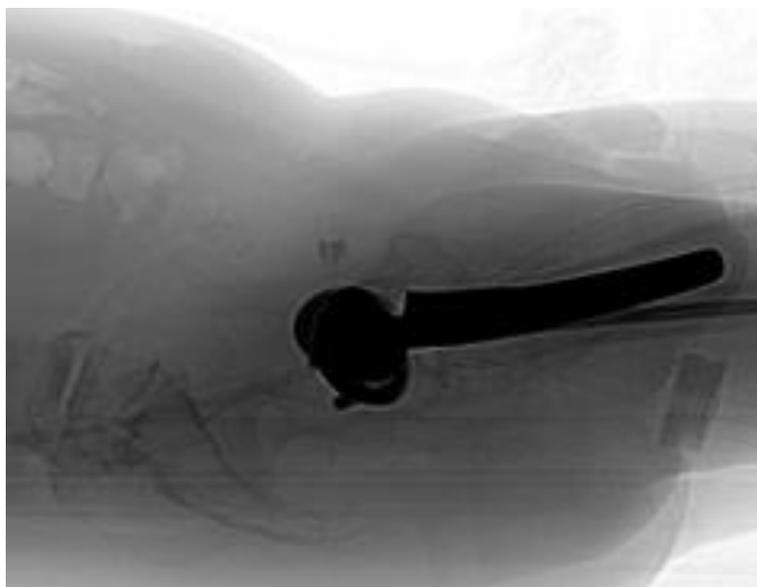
Sagittal fluoroscopic x-ray image of implanted plastic needles in bilateral hip prosthesis patient. Note needle template on perineum, needle tips obscured by prosthesis.
